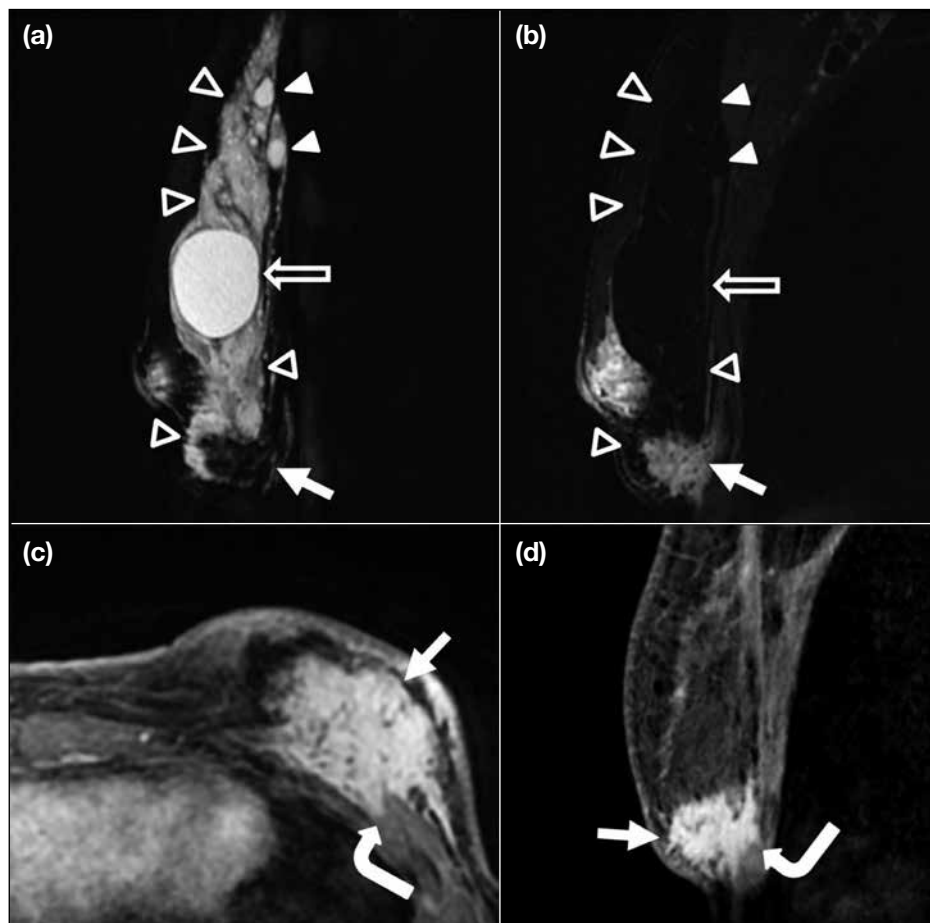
(a) Sagittal silicone-only T2-weighted fat- and water-saturated sequence and (b) sagittal silicone suppressed T2-weighted fat- and water-saturated sequence in the same plane confirm presence of free silicone (open arrowheads), some as tiny locules (arrowheads), and one larger locule (open arrows) corresponding to prior mammogram-detected circumscribed mass at left upper breast. The index mass at left 5 o'clock (arrows) position is also visualised. (c) Axial and (d) sagittal T1-weighted fat-saturated contrast-enhanced images showing the enlarged irregular enhancing mass lesion (arrows) with chest wall invasion through the pectoralis major muscle, abutting the underlying rib (curved arrows).
